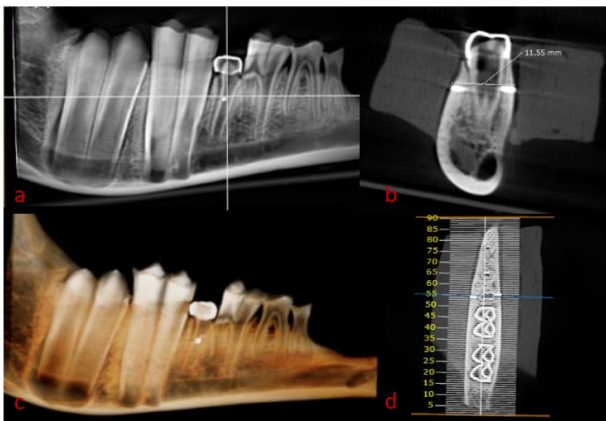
Measurement of bone thickness on the (a) axial, (b) cross-sectional, (c) panoramic, and (d) 3D views of CBCT images
